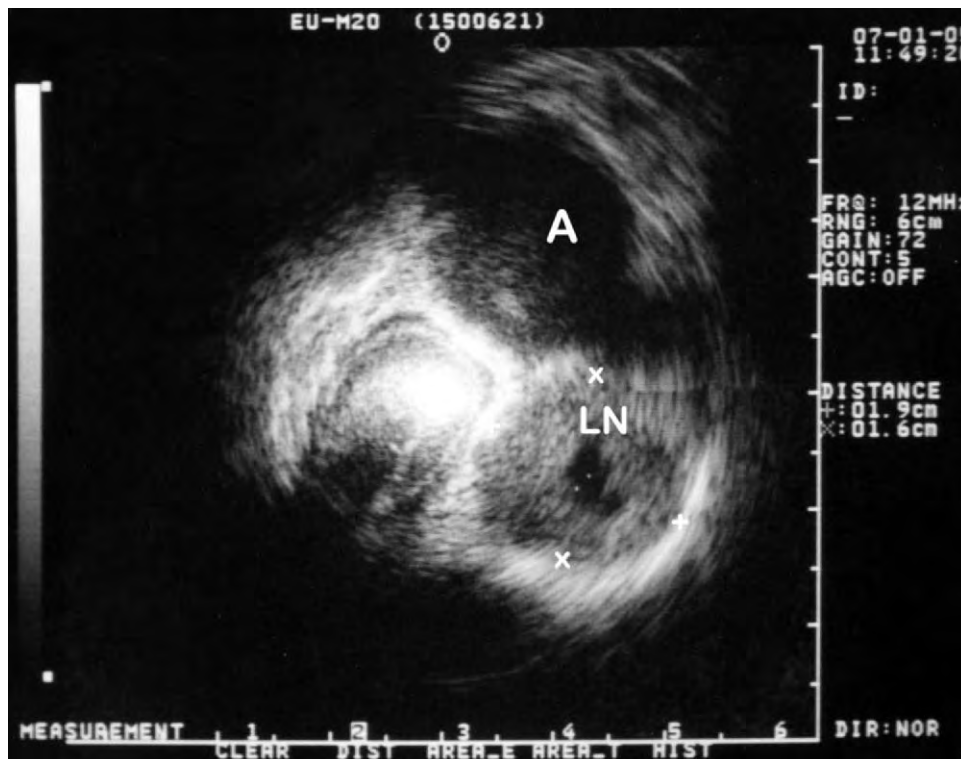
Endoscopic ultrasound image with a 12-MHz miniprobe placed at the gastroesophageal junction showing the aorta (A) and a large 2-cm adjacent lymph node (LN) with central necrosis. (Courtesy of K. E. Kwok, The University of Hong Kong.)
